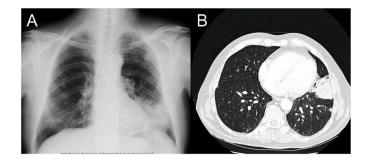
Patient 3 radiological findings. A: Chest radiograph (posteroanterior incidence) shows homogeneous opacity with air bronchogram (left lower lung field) and nodular opacities in the right lower lung field. B: Thorax CT scan shows consolidation with air bronchogram in the lingula.
